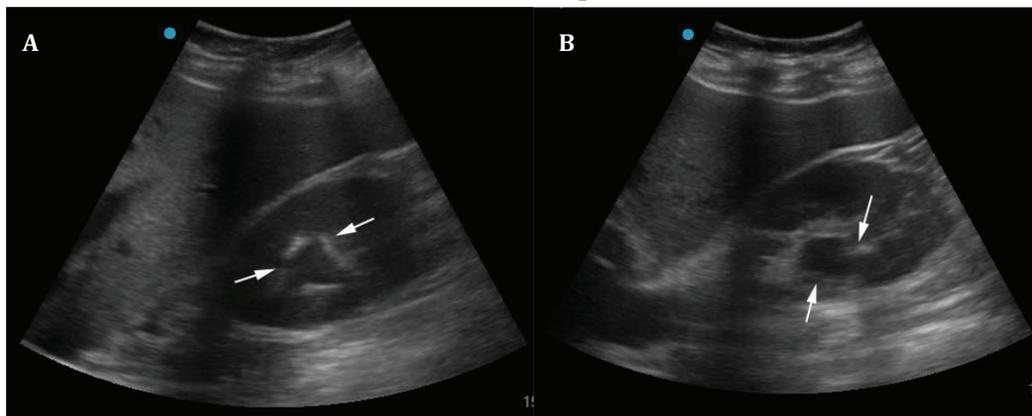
Point-of-Care-Ultrasound (POCUS) of the right kidney demonstrating hydronephrosis (white arrows) (A); and the dilatation of the collecting system of the kidney (white arrows) (B).
